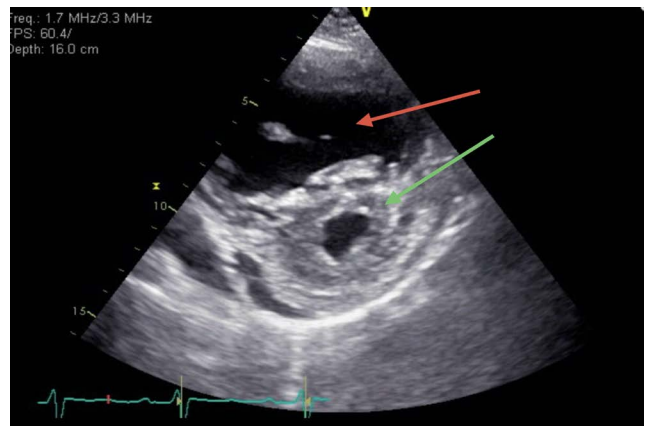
Echocardiogram: Parasternal short axis view demonstrating enlarged right ventricle (red arrow) compared to left ventricle (green arrow) suggestive of pulmonary hypertension
